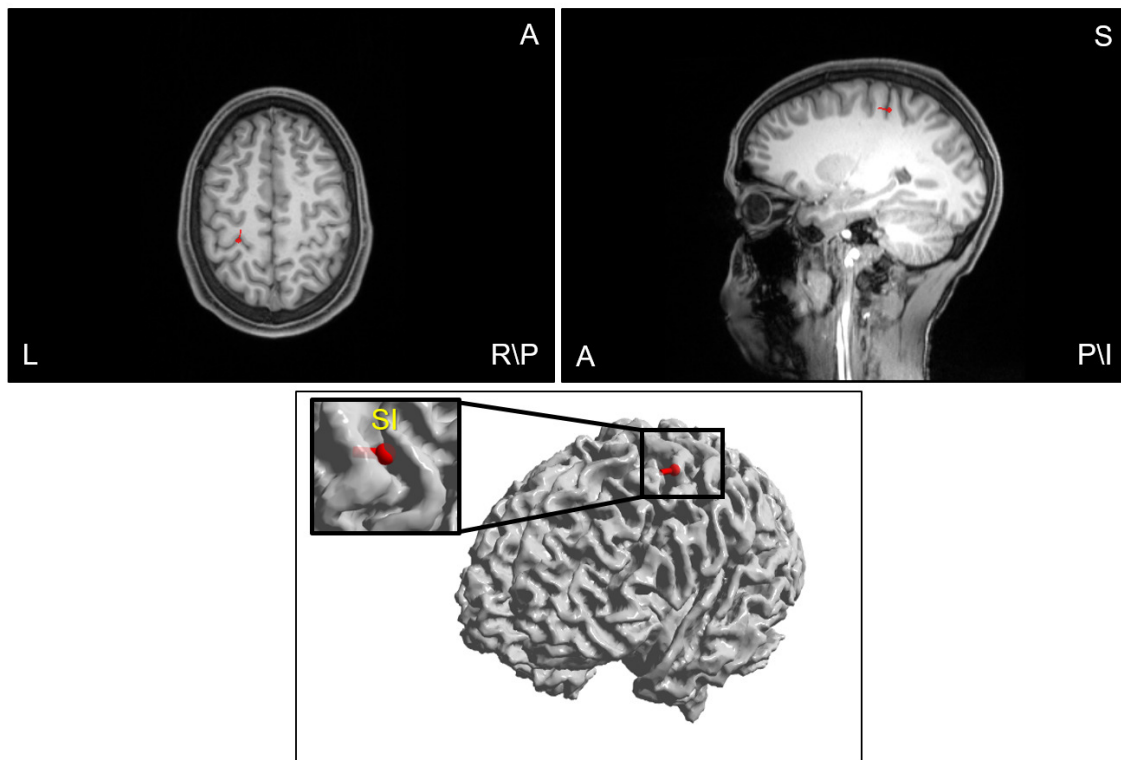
Source reconstruction of the P20/N20 component using combined SEP and SEF: The reconstructed dipole source (in red) is the final result of the skull conductivity calibration procedure of Section 4.1.4.1 applied in one of the subjects of the study. The reconstruction result is presented on axial (left) and sagittal (middle) slices of the subject's T1w MRI and on a 1 mm resolution volume-rendering of the cortical surface (right). The dipole is localized in Brodmann area 3b in SI on the postcentral wall of the central sulcus in the primary somatosensory cortex (SI). Further abbreviations correspond to Superior (S), Inferior (I), Anterior (A), Posterior (P), Left (L) and Right (R).
